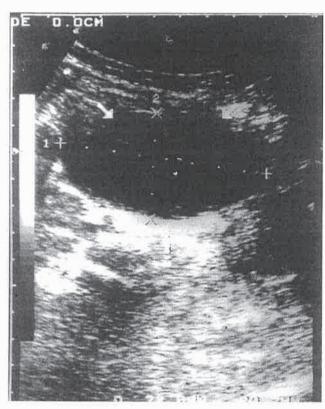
Abdominal ultrasonography revealed a cystic mass in the expected region of the appendix (arrow).
